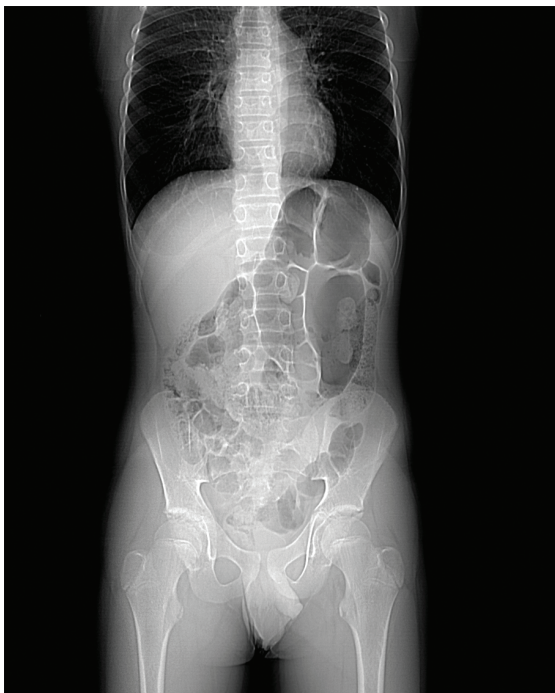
CT scout view presenting 'coffee bean' sign of a sigmoid volvulus
